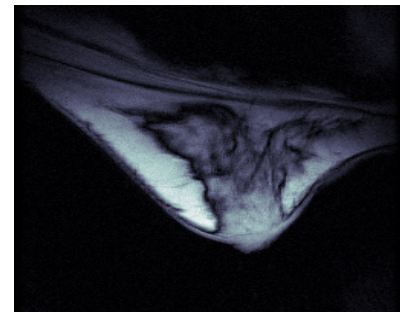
MRI scan of a human breast in the prone position
